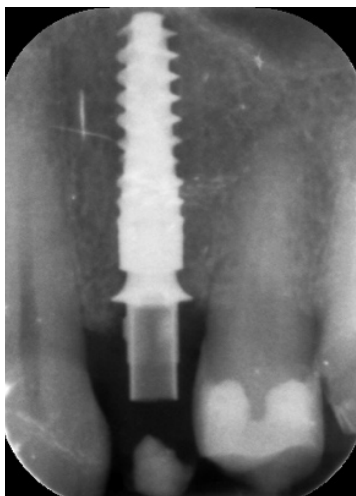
Periapical x-ray at immediate loading.
